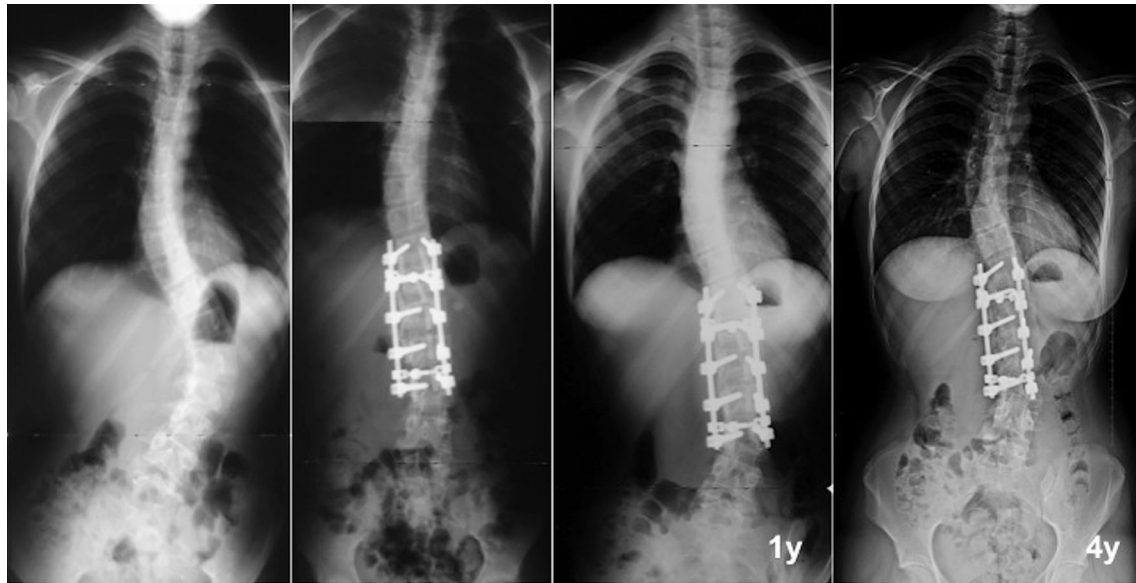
Radiographic example of adding on phenomenon
